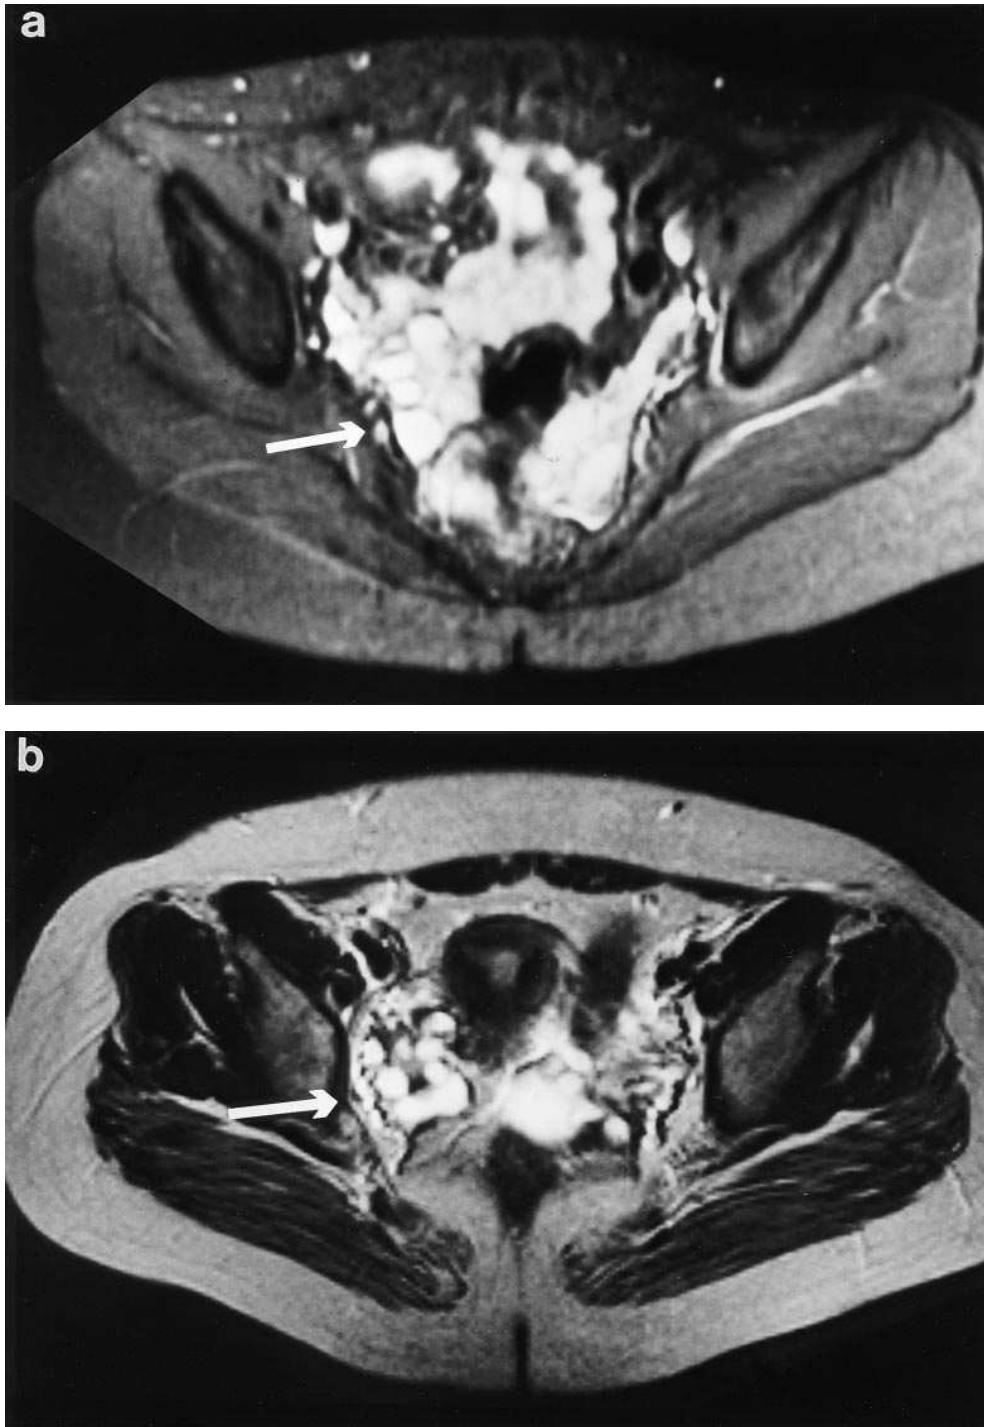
MRI of ovaries in the patients from kindred 1 (a) and kindred 2 (b). MRI was performed on a 1.5-T permanent magnet. The arrows indicate ovaries. In T2w sequence in the axial plane both ovaries are enlarged with many cysts occupying the entire volume of the ovary and hypertrophied ovarian stroma.
